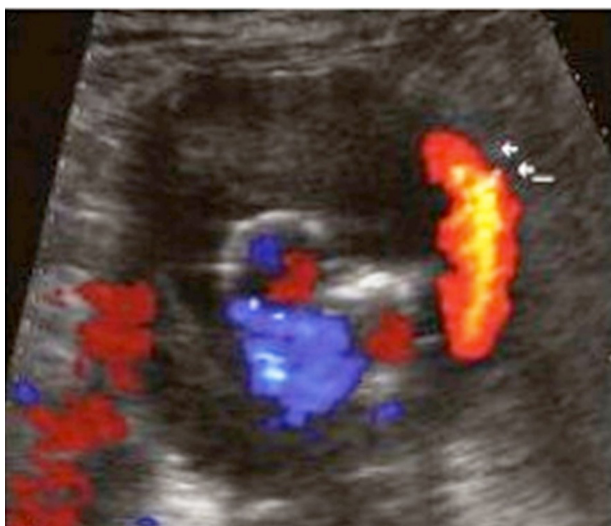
Abdominal aortic Doppler US follow-up after aneurysm treatment with endoprosthesis: Doppler US signal in the exclude aneurysm by a type-2 endoleak due to inferior mesenteric artery reinjection.
